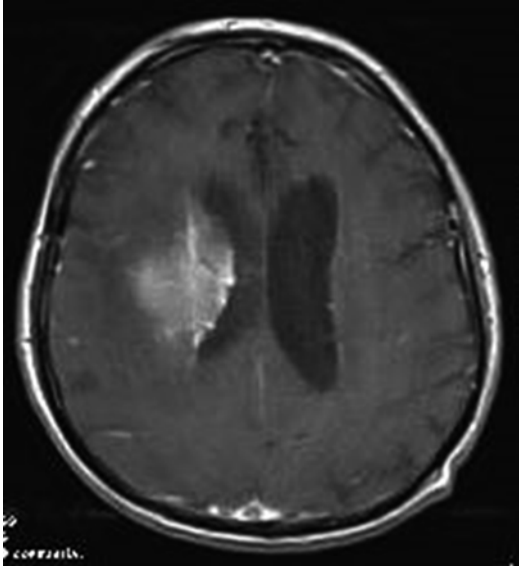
T1-weighted image post contrast medium administration, showing an area with intense enhancement in the right periventricular area, a finding more compatible with recurrence
